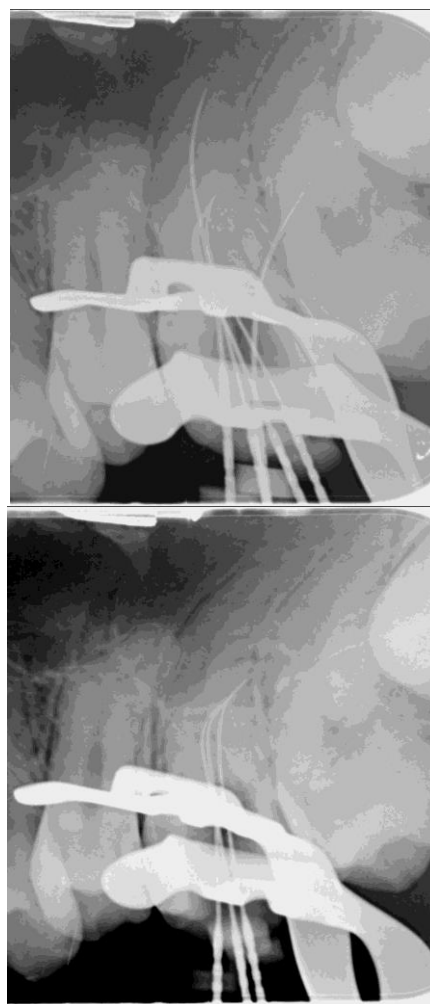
Periapical radiograph: Evidence of 3 mesiobuccal canals noted at the mesio-buccal root.
